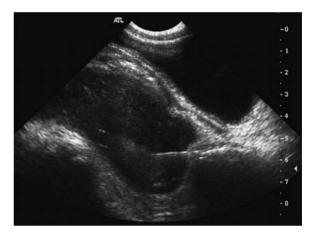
An 8-year-old boy with a perirectal appendiceal abscess. The image shows the needle positioned, using ultrasound guidance, through the posterior rectal wall within the abscess (courtesy of Dr. L. Fontalva, Hospital for Sick Children, Toronto, Canada)
